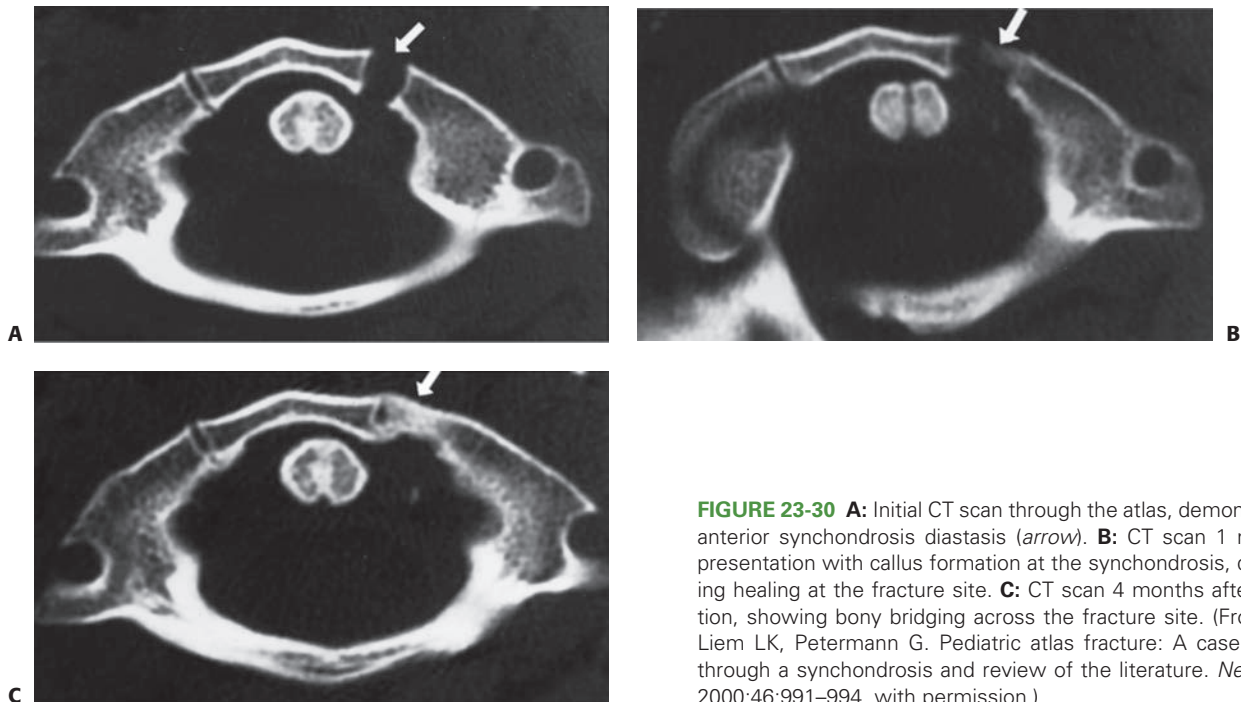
A: Initial CT scan through the atlas, demonstrating left anterior synchondrosis diastasis (arrow). B: CT scan 1 month after presentation with callus formation at the synchondrosis, demonstrating healing at the fracture site. C: CT scan 4 months after presentation, showing bony bridging across the fracture site. (From Judd D, Liem LK, Petermann G. Pediatric atlas fracture: A case of fracture through a synchondrosis and review of the literature. *Neurosurgery*. 2000;46:991–994, with permission.)
